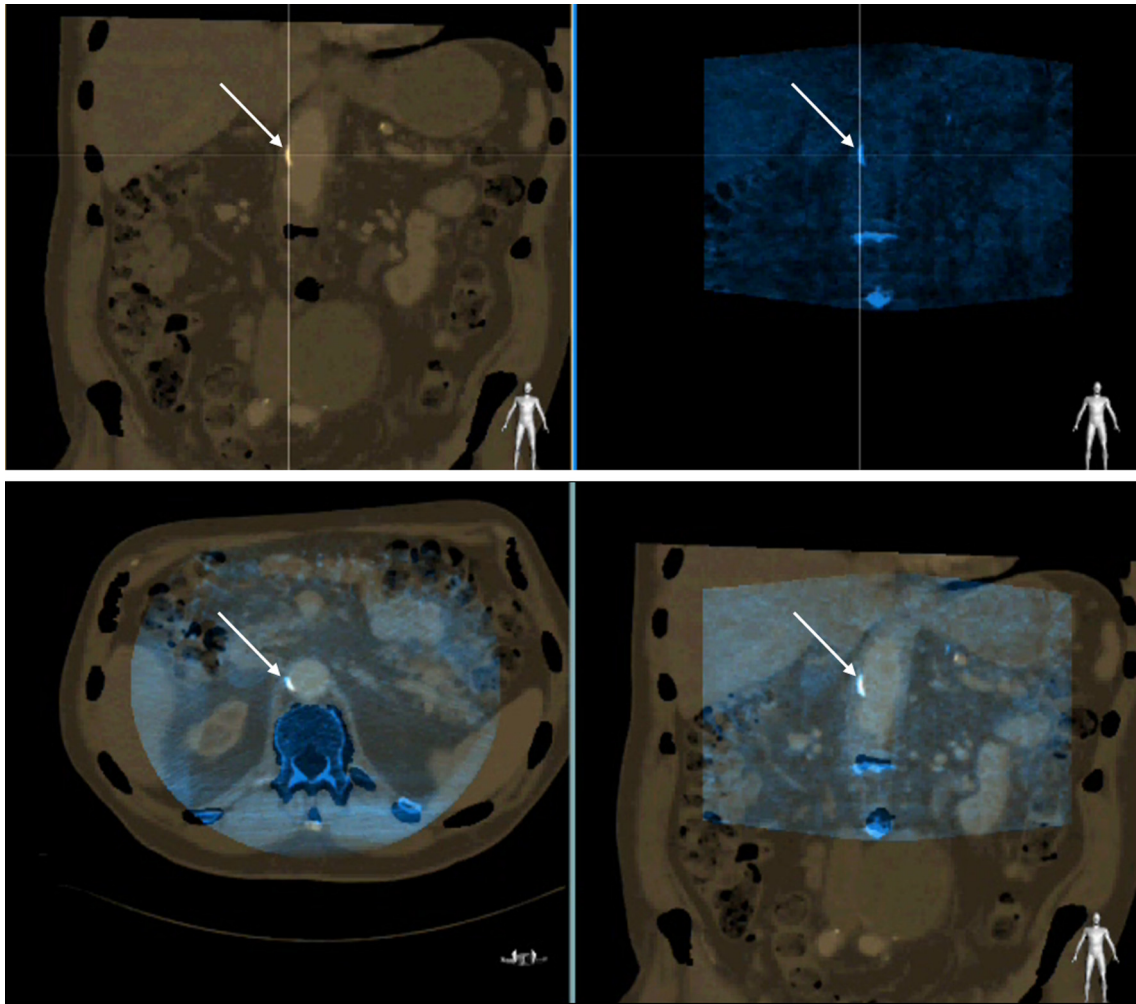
Three dimensional co-registration of volumetric pre-acquired computed tomography angiography (CTA) dataset (grey) with cone beam computed tomography (CBCT) dataset (blue). Top row: Aortic wall calcifications (white arrows) on CBCT and CTA datasets are selected as landmarks and marked with the crosshair. Bottom row: The fused dataset is further adjusted in three dimensions by scrolling through the dataset and aligning bone borders and other calcifications (sagittal plane not shown).
